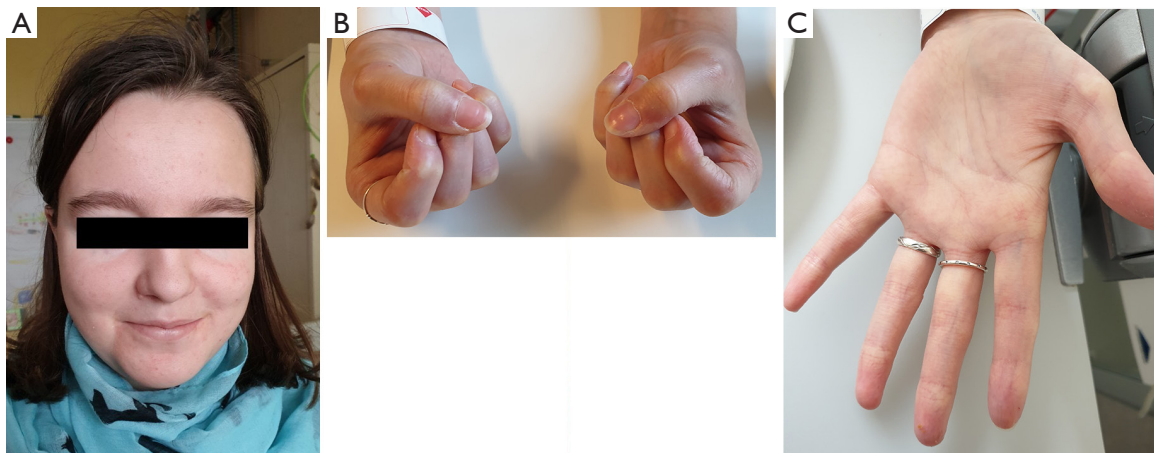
Typical clinical findings of systemic sclerosis in a teenaged girl who presented with evidence of PAH at echocardiographic examination and an elevated NT-pro BNP level of 1,286 ng/L (normal: <97 ng/L). She reported of general weakness, painful knee and wrist movement, paleness of fingers, loosening of hairs, and difficulties in swallowing resulting in weight loss of 5 kg in 6 weeks. (A) Symmetrical facial skin tightening; (B) painful limitations of motion in both wrists and flexion contractures in all metacarpophalangeal and proximal interphalangeal joints; (C) Raynaud's phenomenon.
